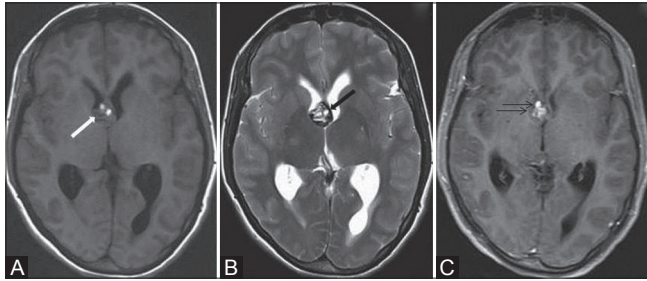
(A-C): Magnetic resonance image (MRI) reveals a relatively well-delineated anterior third ventricular mass located at the foramen of Monro, showing heterogeneous signal intensity with hyperintense hemorrhagic areas (white arrow) within on axial T1WI (A). Typical peripheral hemosiderin rim of low signal intensity (black arrow) is seen on T2WI (B). Post-contrast T1WI image shows mild heterogeneous enhancement (double arrow) of the lesion (C)
